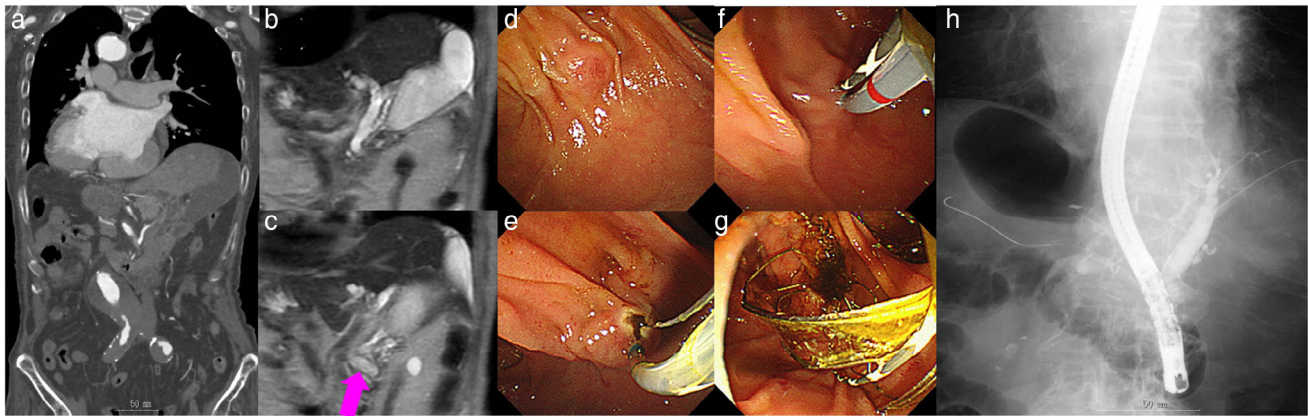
(a) Computer tomography (CT) findings. Left to right reversal of the organs due to situs inversus viscerum is evident. (b,c) Magnetic resonance cholangiopancreatography (MRCP) findings. Reduced signal intensity in the distal bile duct was seen (arrow), indicating the presence of biliary sludge. (d) Duodenal papilla. (e,h) Pancreatic guidewire placement for achieving selective biliary cannulation was performed, which successfully achieved deep biliary cannulation. (f,g) Endoscopic sphincterotomy was performed, and the stones were successfully removed.
